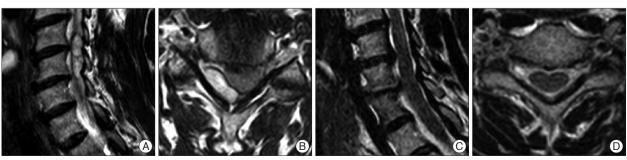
T2 oblique sagittal (A) and axial (B) MRI of a patient treated with conservative management. T2 oblique sagittal (C) and axial (D) magnetic resonance images after a 1-month follow-up demonstrate the disappearance of the epidural hematoma.
